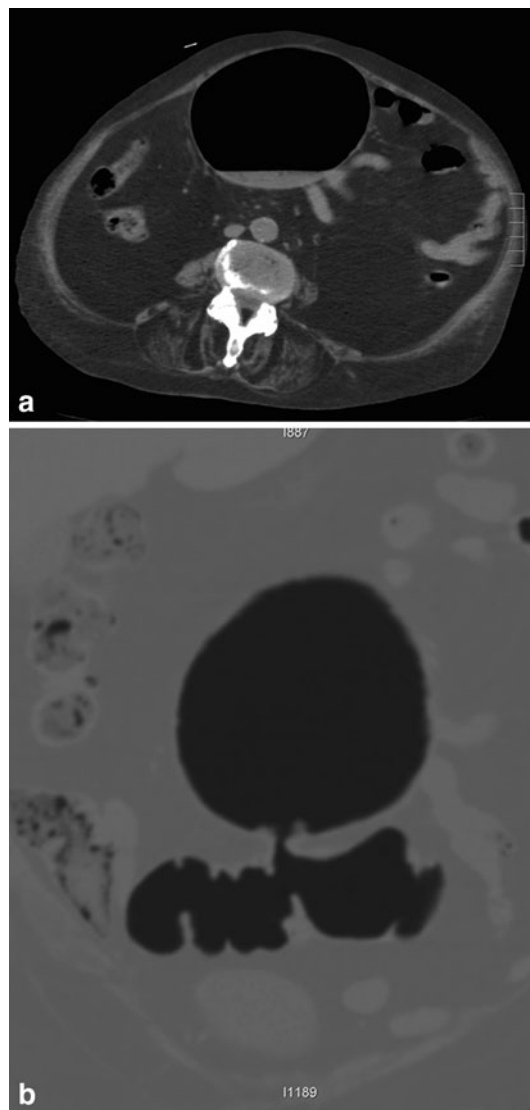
Subsequent unenhanced axial CT scanning confirms the presence of an air-filled mass with thin regular walls, a small quantity of fluid in the inner part (a) and direct communication with the sigmoid colon, as confirmed by coronal 2D MPR (b)
